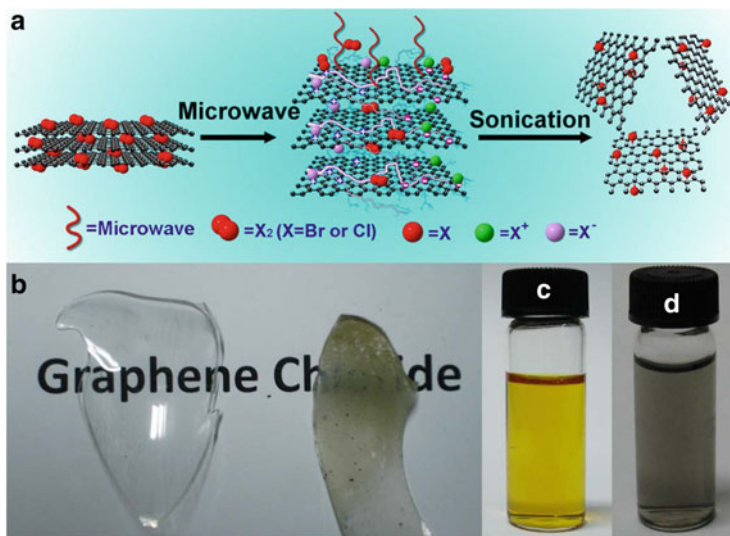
(a) Scheme showing sequential MW-assisted graphite halogenation followed by ultrasound-promoted exfoliation. Photographs of graphite chloride (b), a graphite chloride dispersion in DMF (c), and graphite bromide dispersion in DMF (d). Reproduced with permission from [70]. Copyright 2012 Macmillan Publishers Ltd
